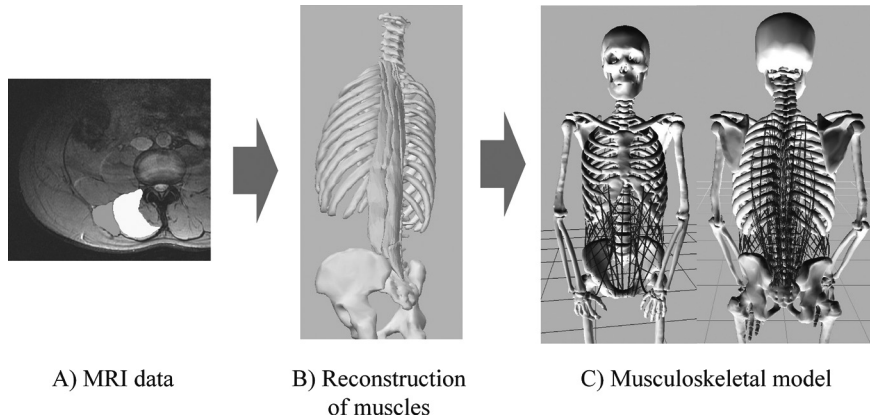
The musculoskeletal model. A) Muscle area was extracted from MRI data. B) The muscle model was reconstructed from MRI data using Mimics software. The reconstruction methods allowed analysis of muscle cross-sectional area and muscle paths. C) The musculoskeletal model for the whole body was reconstructed using EICAS software.
